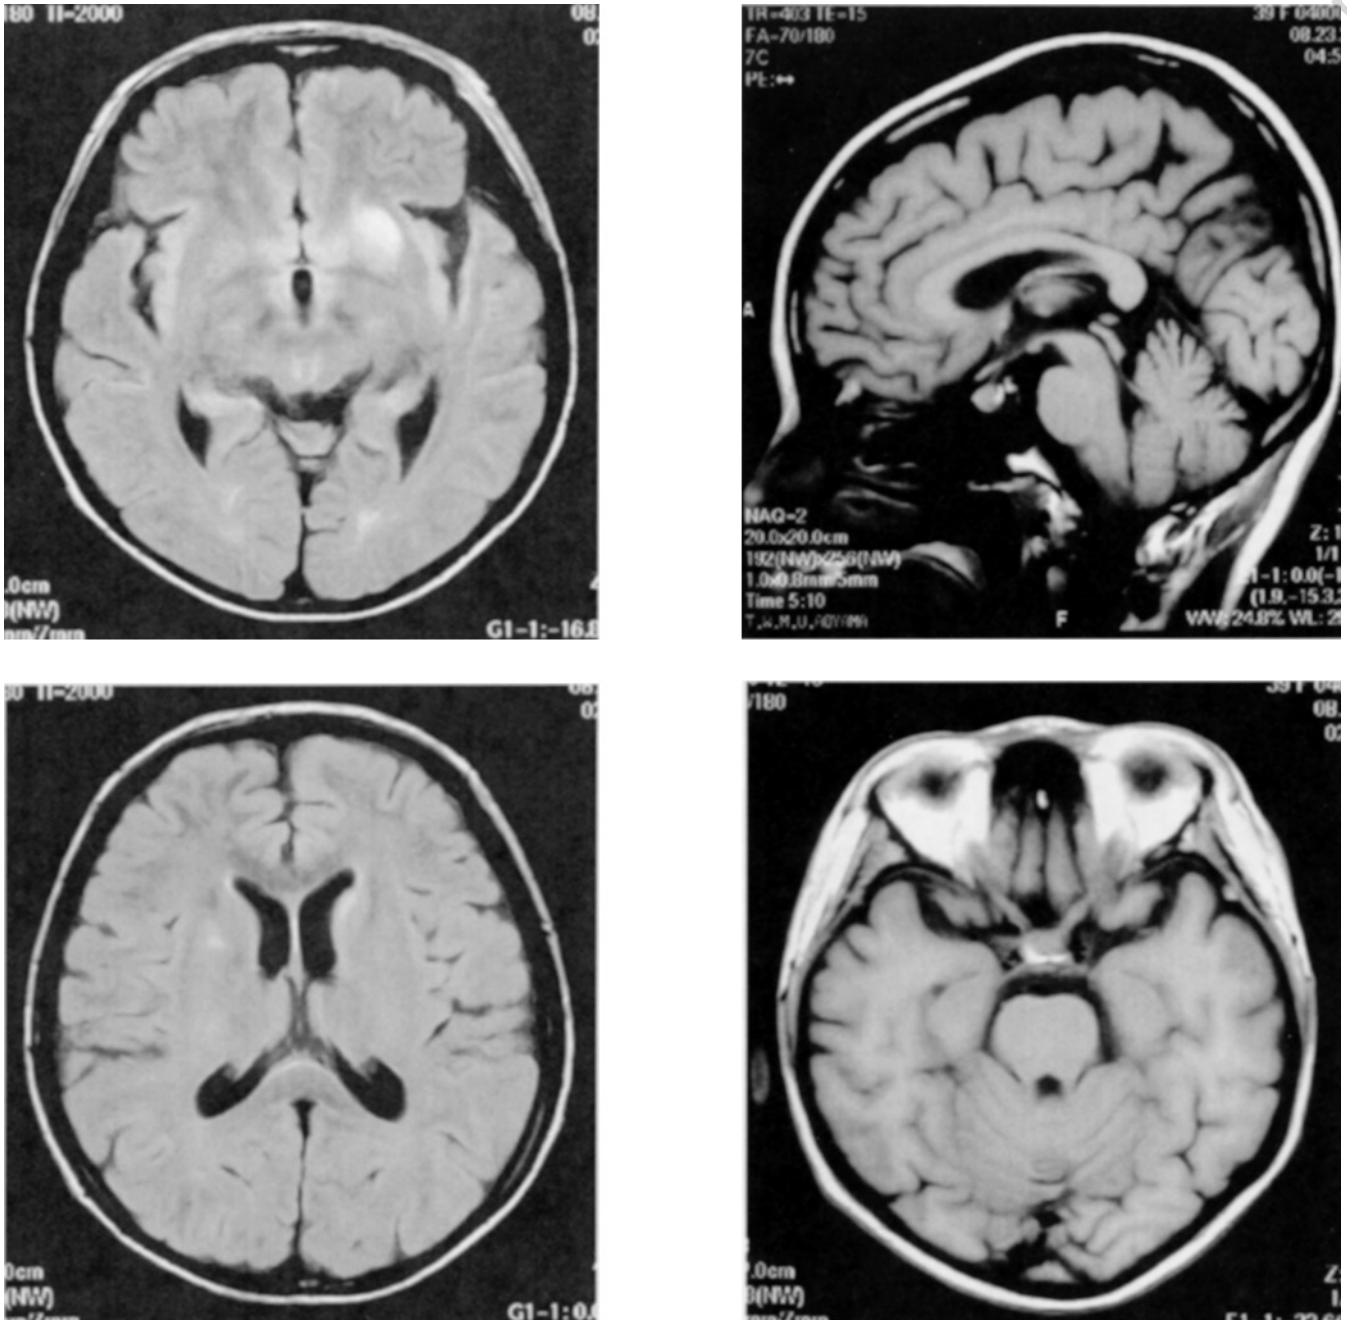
MRI of the brain. Left panel: fluid attenuated inversion recovery imaging of MRI showing CNS lesions of lupus. Right panel: T1 image showing the intact bright signal in the neurohypophysis.
